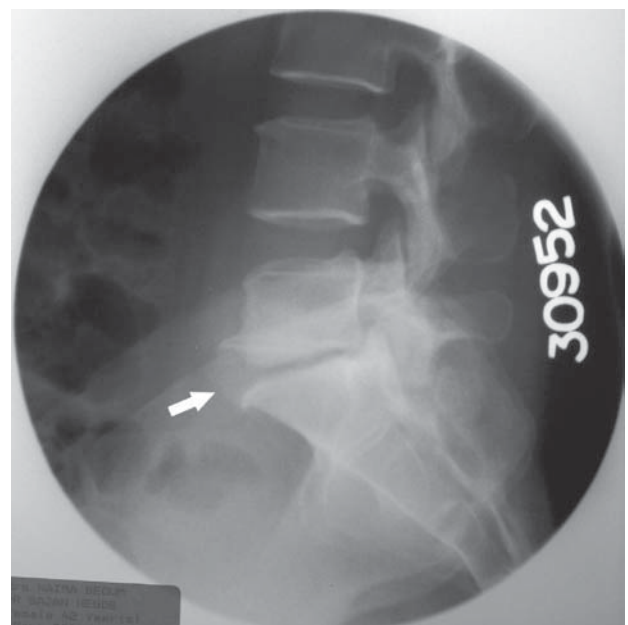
X-ray showing degenerated disc with space reduction at L5-S1 level (arrow), other levels show normal disc height.
